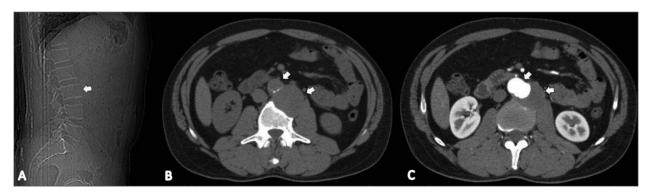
Lateral radiograph of the lumbar spine demonstrating the radiolucency in the anterior part of L3 vertebra (A). Unenhanced (B) and enhanced (C) computed tomography showing chronic contained rupture of the saccular aneurysm arising from the abdominal aorta. The aneurysm (39×42 mm) has a mural thrombus causing scalloping in the left anterolateral part of L3 vertebral body.
